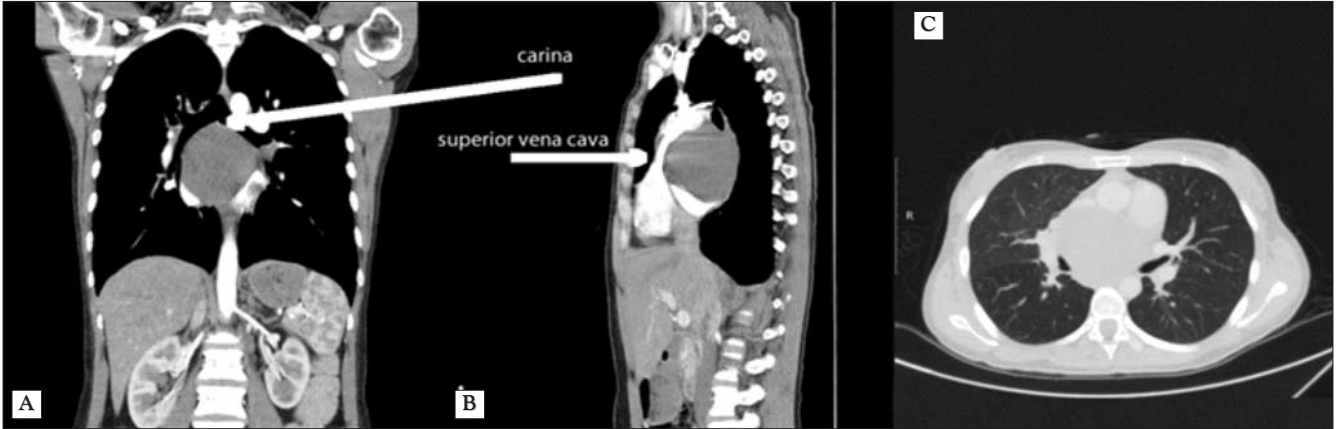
Angio-CT aspects of a mediastinal mass, with its upper limit inferior to carina (A), compressing the superior vena cava (B); detail of lung parenchyma (C).
